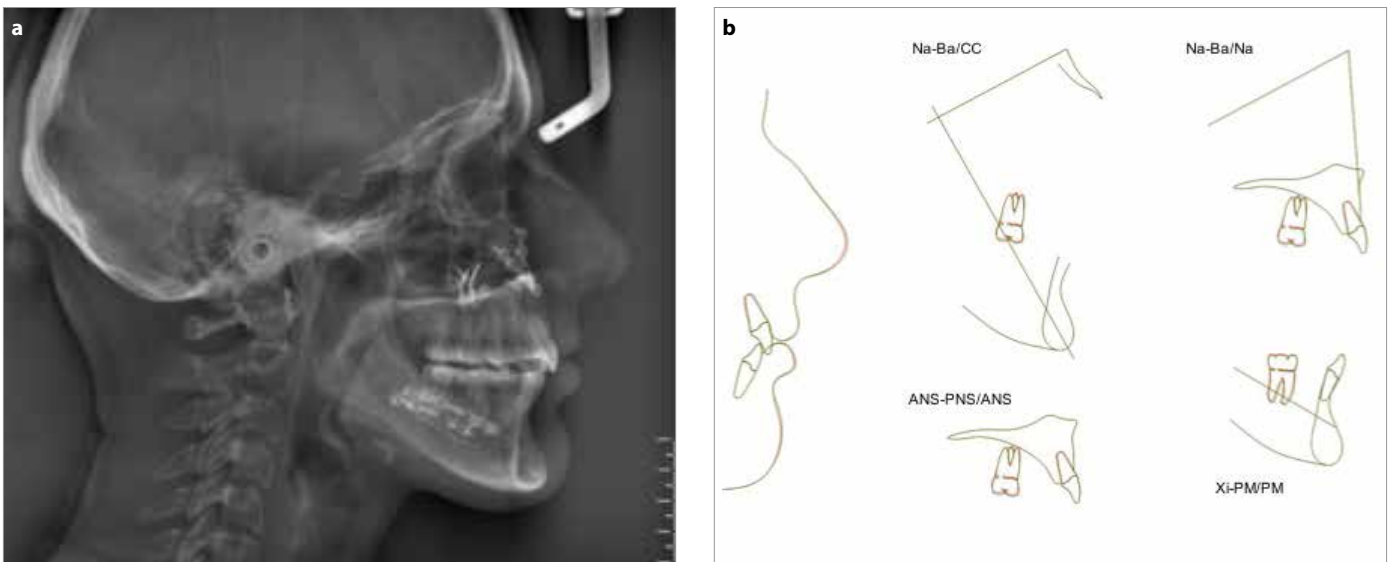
a, b. Lateral cephalometric radiograph 1 year after treatment Postoperative (a); 1-year post-retention lateral cephalometric superimpositions (b) Red: postoperative; green: 1-year post-retention
